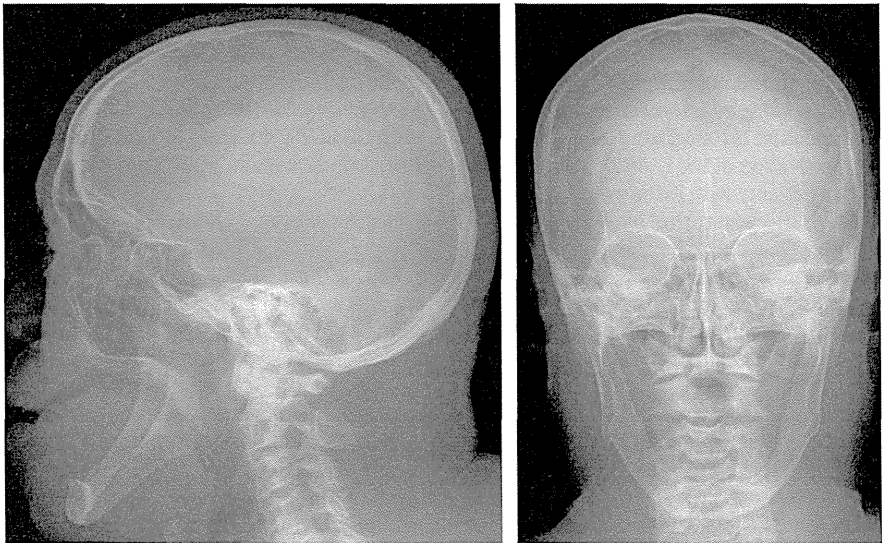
Skull radiographs at the age of 61 years. Note the absence of teeth.
